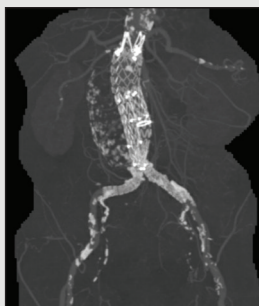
Postoperative CTA at 1 month showing a patent EVAR and no evidence of endoleak.
